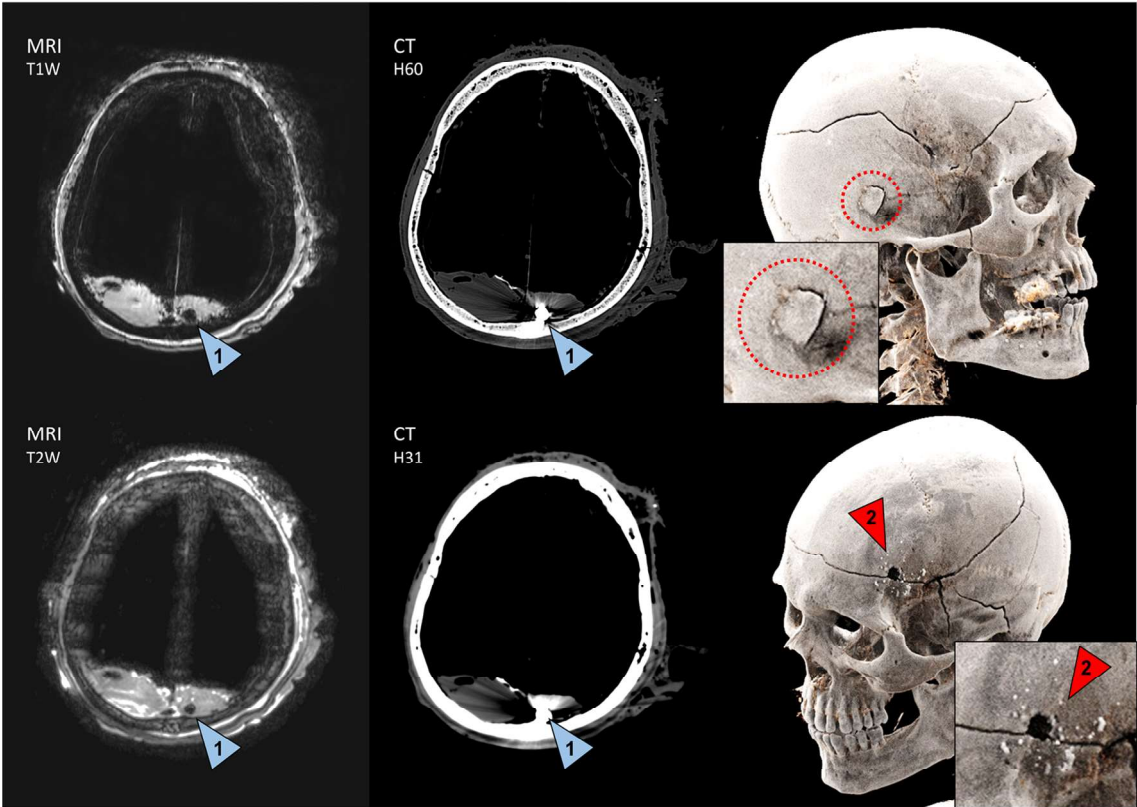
Case no. 11 underwent imaging in an advanced state of decomposition (left column: MRI T1-weighted (T1W) and T2-weighted (T2W); middle column: CT bone (H60) and soft tissue (H31); right column: CT cinematic renderings). The retained bullet is visible on CT and MRI (no.1: blue arrowheads). At this stage of decomposition, the soft
